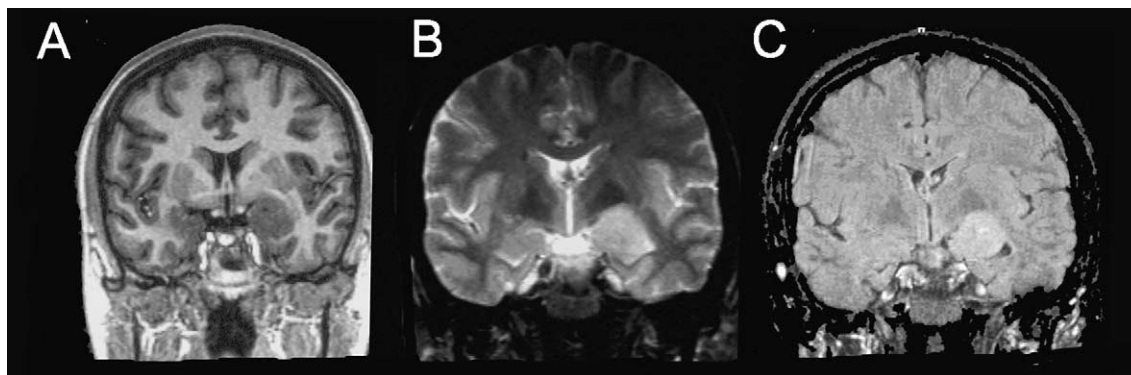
MRI of a 22 years woman with intractable temporal lobe epilepsy secondary to a hamartoma. The patient had two to three complex partial seizures per month with rare secondary generalization since the age of 19 years. The MRI shows a mass in the left amygdala and hippocampal body. Signal characteristics are: isointense on T1 (A), hyperintense on T2 and FLAIR (B and C).
